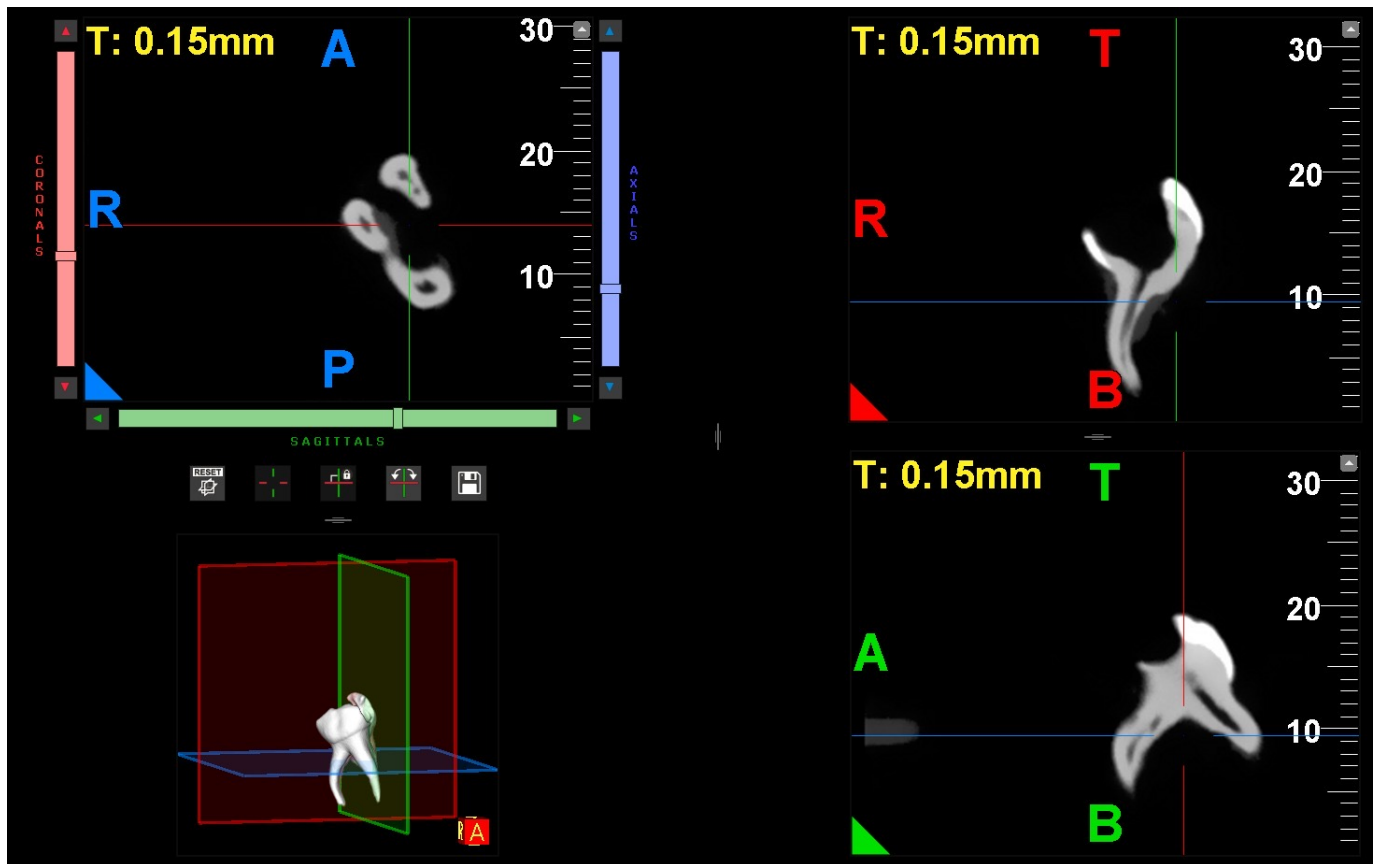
Coronal and axial section of the sample in the CBCT. A: Anterior; R: Right; P: Posterior; T: Top; B: Bottom.
